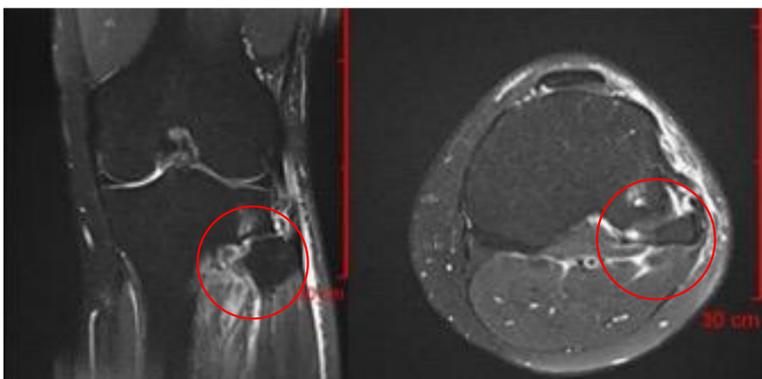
Coronal and transverse MRI views of the patient's injured left knee. The image shows an increased signal in the proximal tibial facet and surrounding soft tissues.
